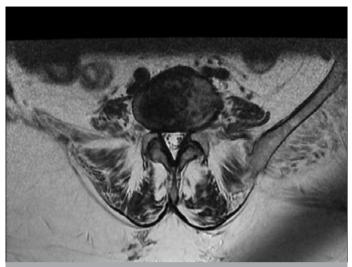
Axial MRI section of hip MRI: magnetic resonance imaging
